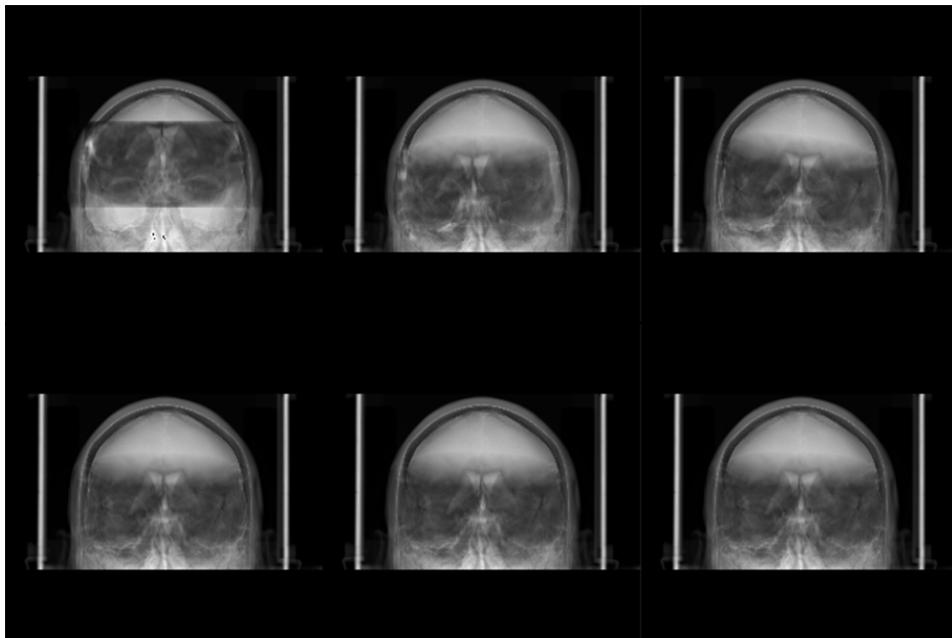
Using the GPU accelerated method based on a gradient descent approach the system automatically fuses the MRI and CT images in milliseconds. Top left: starting position; Bottom right: Final registration.
